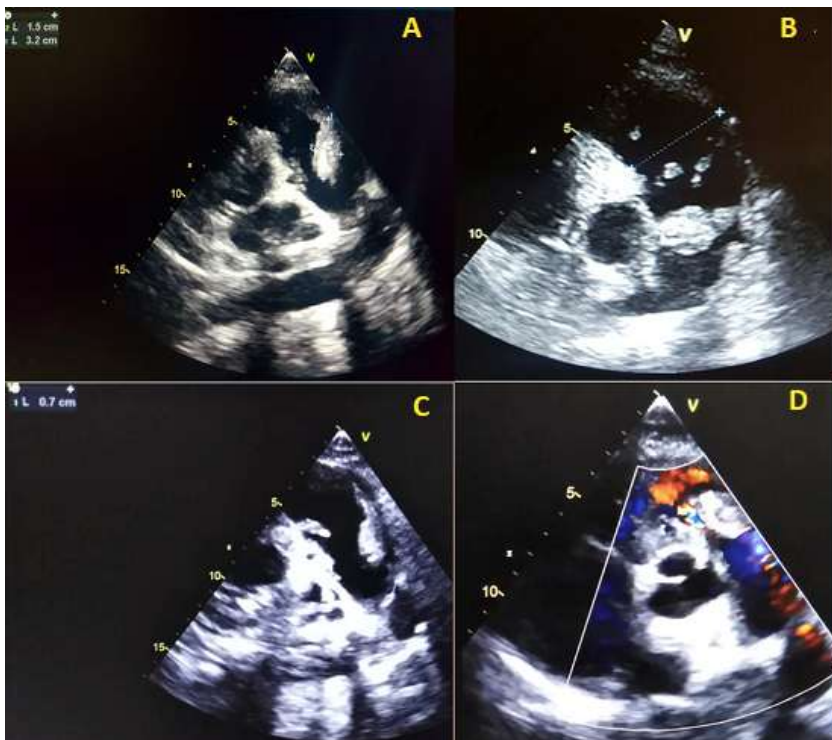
transthoracic echocardiography showing (A) large highly mobile pulmonic valve vegetation measuring 32×15 mm (B) with dilated pulmonary artery and right ventricle infundibulum (C) and a 7 mm patent ductus arteriosus (D) and severe pulmonary regurgitation
